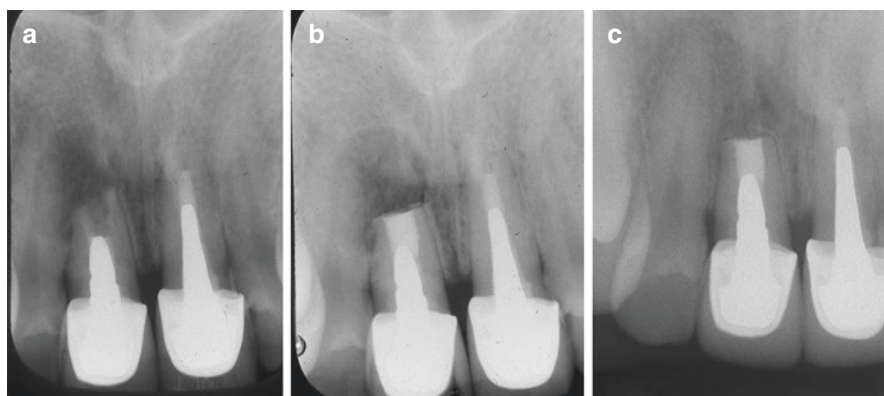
A healthy 23-year-old male presented with a draining sinus tract associated with tooth #8 (a). Periodontal probings were WNL and the tooth exhibited class 2 mobility. The radiographic appearance is suggestive of previous surgical treatment but no evidence of a root-end filling material. Extraction and implant placement was recommended, but financial concerns prevented the patient from accepting this treatment option. An alternative option of endodontic microsurgery, with questionable prognosis, was presented and accepted. Endodontic microsurgery with minimal root-end resection and mineral trioxide aggregate (MTA) root-end filling was performed (b). (c) 6-month posttreatment evaluation radiograph and demonstrates good initial healing and bone regeneration. Mobility was reduced to class 1 (Case courtesy of Dr. Shawn Velez)
